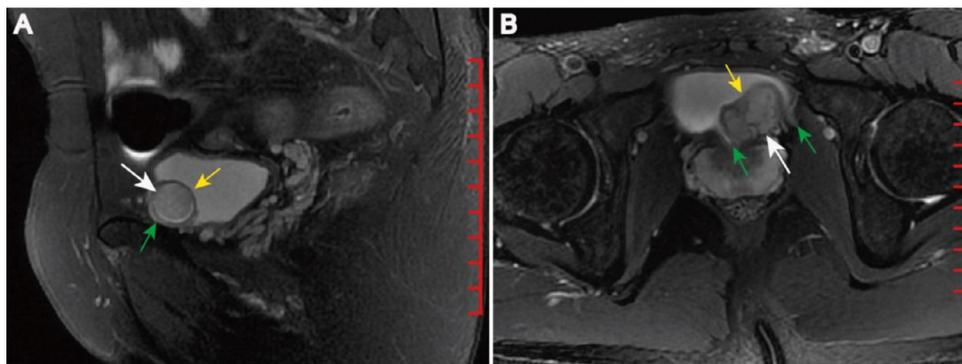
MRI of PUBs. Both A (sagittal MRI, T2WI) and B (axial MRI, T2WI) demonstrate the gaps between the tumors and the mucosae as well as the continuities of mucosae (yellow arrow). A shows the continuous serosa (green arrow), while B does not.
